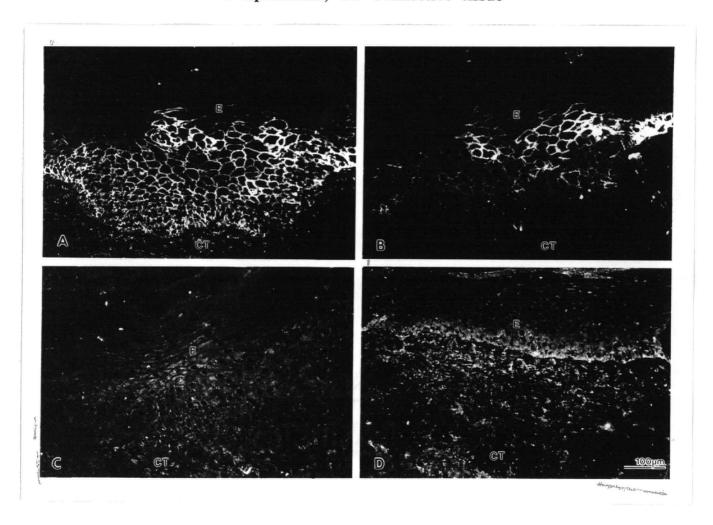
Localization of (A) αv , (B) $\beta 6$, (C) $\beta 3$, (D) $\beta 5$ in lichen planus tissues E=Epithelium, CT=Connective tissue
